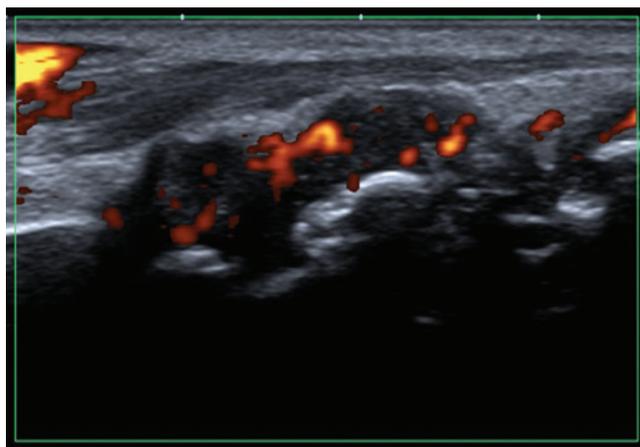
Ultrasound, longitudinal view of the radiocarpal and midcarpal joints: synovitis and erosions
